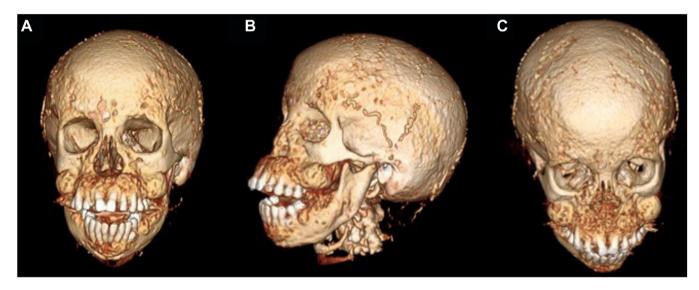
Three-dimensional computed tomography coronal (*A*), sagittal (*B*), and superior (*C*) images of the head showing extensive bone deformities predominantly of the mandible, maxilla, and calvaria with overbite. Diffuse mixed sclerotic and lytic changes in all visualized bone noted.
